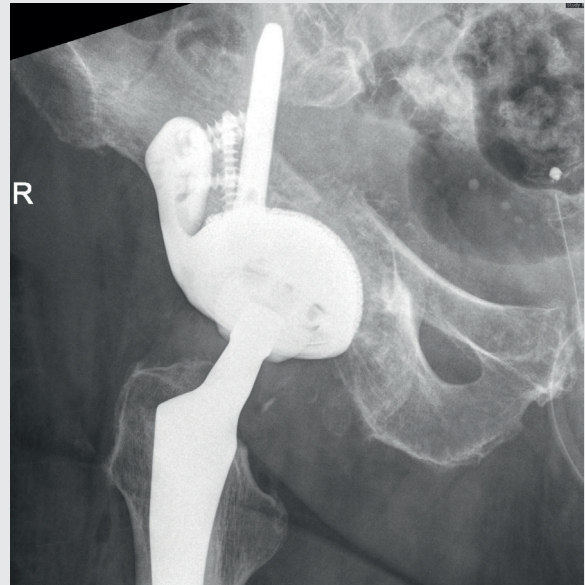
Postoperative follow-up radiograph with MRS-TITAN Maximum revision cup, screw fixation, and iliac peg.
